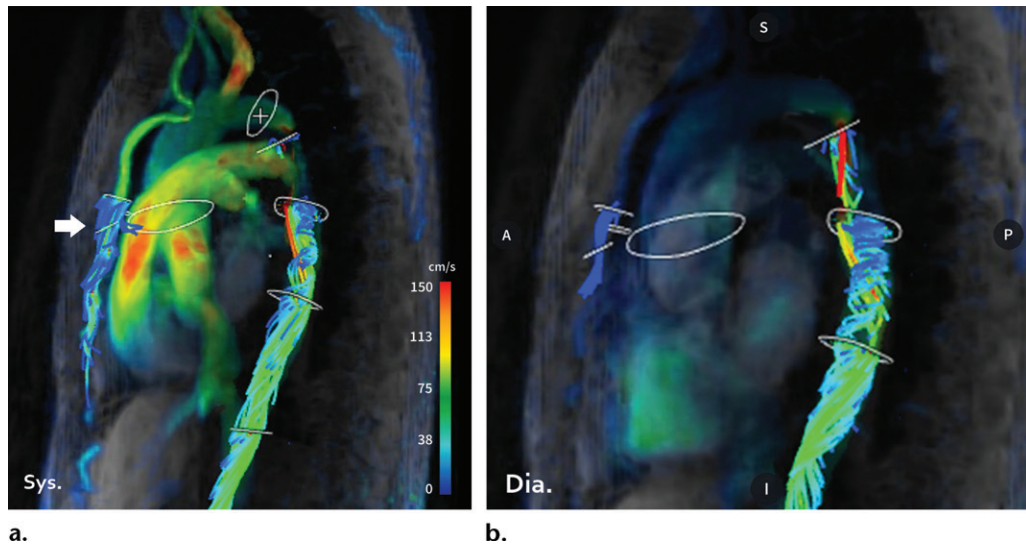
Cardiac 4D flow MRI of aortic coarctation in a 38-year-old man with systemic hypertension. Images with streamlines during systole (*Sys*) (a) and diastole (*Dia*) (b) show continuous systolic-diastolic low flow with a helical pattern downstream of the coarctation. Collateral flow through the large internal mammary arteries (arrow in a) was assessed and found to equal 35% of the flow through the descending aorta.
